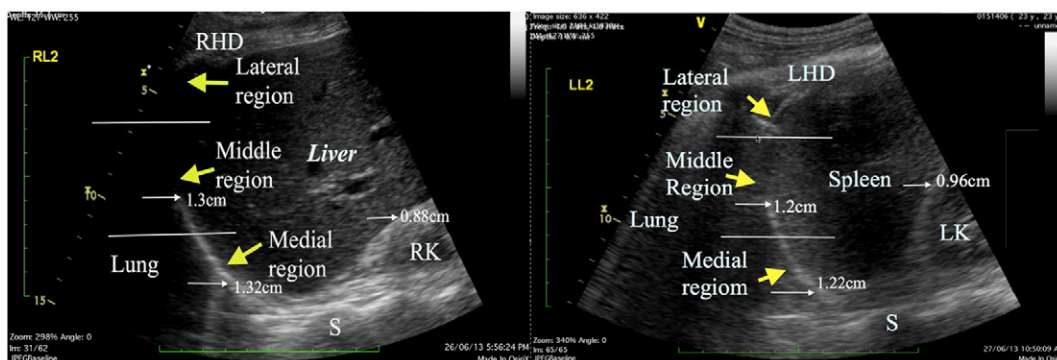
Two-dimensional mode ultrasound of the right hemidiaphragm, liver, left hemidiaphragm, and spleen. The ultrasonographic images of the diaphragm divided in 3 different regions, the anterior ultrasonographic middle and medial third, spleen, and liver. RHD indicates right hemidiaphragm; RK, right kidney; LHD, left hemidiaphragm; LK, left kidney; S, spines.
